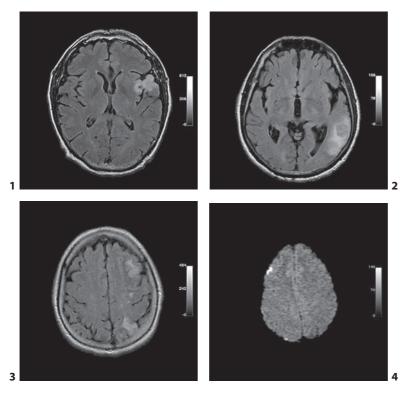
Cranial MR FLAIR T₂ sequences show a left insular ischemic lesion (anterior or superior trunk) in a 59-year-old male with interatrial communication admitted due to motor dysphasia. Fig. 2. Cranial MR FLAIR T₂ sequences show a left temporoparietal ischemic lesion (posterior or inferior trunk) in a 67-year-old male with sensitive dysphasia and atrial fibrillation. Fig. 3. Cranial MR FLAIR T₂ sequences show a left parietal ischemic lesion in a 43-year-old female with an intracranial internal carotid dissection admitted due to headache and behavioral impairment. Fig. 4. Cranial MR diffusion sequences show small right
